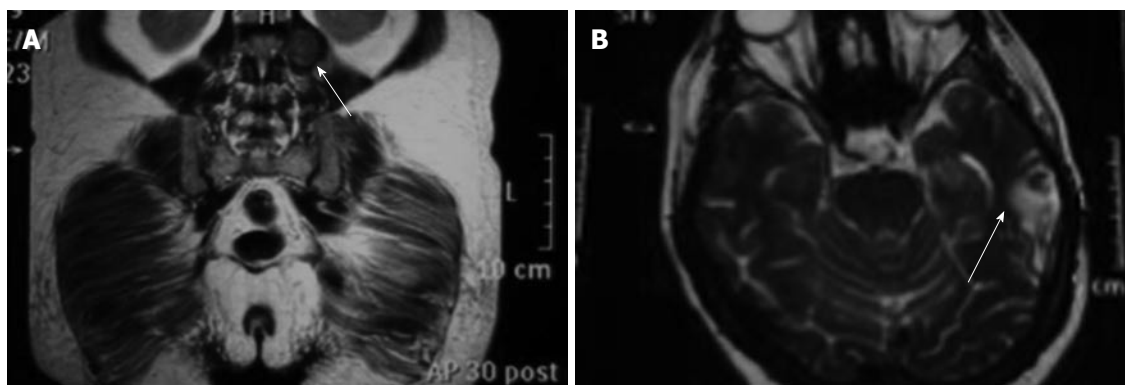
Magnetic resonance imaging. A: A contrasted mass on the left psoas muscle identified from abdomen magnetic resonance imaging (arrow); B: A metastatic brain lesion located in the left temporo-parietal region identified from brain magnetic resonance imaging (arrow).
